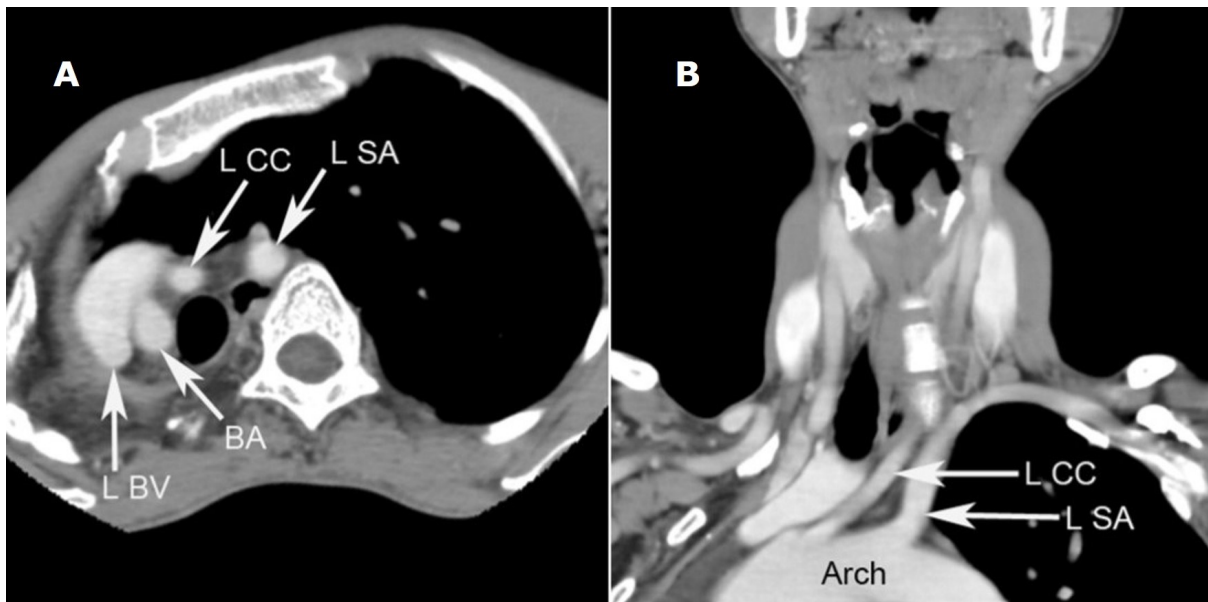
and 2B: CT angiography of the great vessels in axial plane (A) and reconstructed in coronal plane (B). (LSA=left subclavian artery, LCC=left common carotid artery, BA=brachiocephalic artery, LBV=left brachiocephalic vein.) Severe displacement of the great vessels is depicted, with the aortic arch and ostia of all the great vessels located right of midline. Note also the counterclockwise rotation of the great vessels and aorta (usually showing an oblique posteroanterior course; it now displays a horizontal course as seen in B). An increased distance is noted between the left subclavian and common carotid arteries, most plausibly explained by the rotation. The left vagus nerve descends the neck within the carotid sheath and crosses the left subclavian artery, entering the thorax between the left common carotid and subclavian arteries. The left RLN loops around the aortic arch (distal to the ligamentum arteriosus) and enters the aortopulmonary window (asterisk in B), indicating that left RLN nerve is now located to the right of midline which been susceptible to stretch injury.
